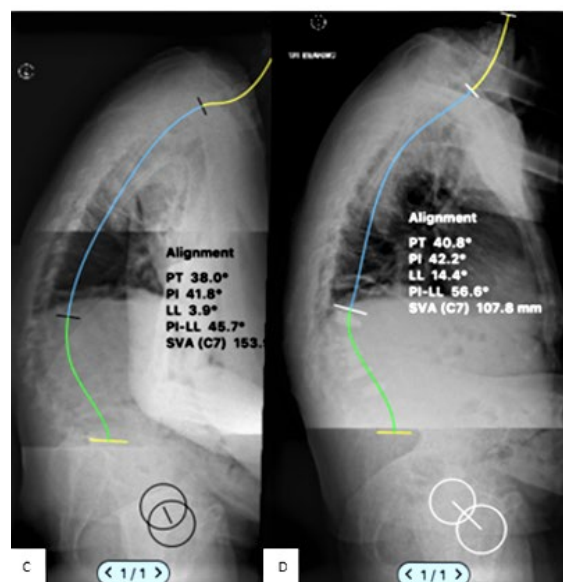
Sagittal view of MRI (STIR) images of Lumbar spine of newly diagnosed myeloma of a 60-year-old male with rapidly progressing VCFs of T12 L1 L2 L3 & L4 (A). Post-operative X-ray lateral view of Lumbar spine after cement augmentation with Titanium mesh cages (B). Pre-operative & Post-operative Whole spine X-rays demonstrating improvement of sagittal alignment with improvement in lumbar lordosis and Sagittal Vertical Axis (D).
